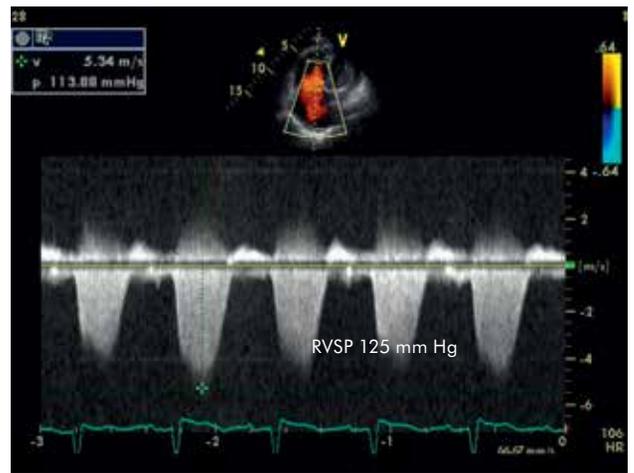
Echocardiography. Measurement of tricuspid regurgitation wave velocity to estimate right ventricular systolic pressure
